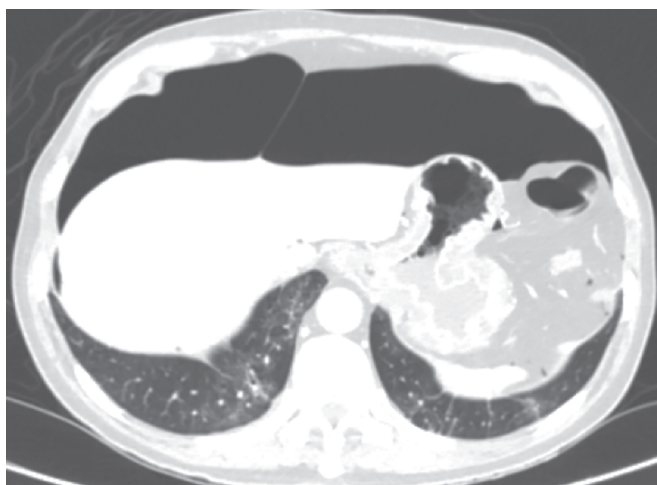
Computed tomography scan section of the upper abdominal showing the pneumoperitoneum and the absence of associated pneumothorax or pneumomediastinum
